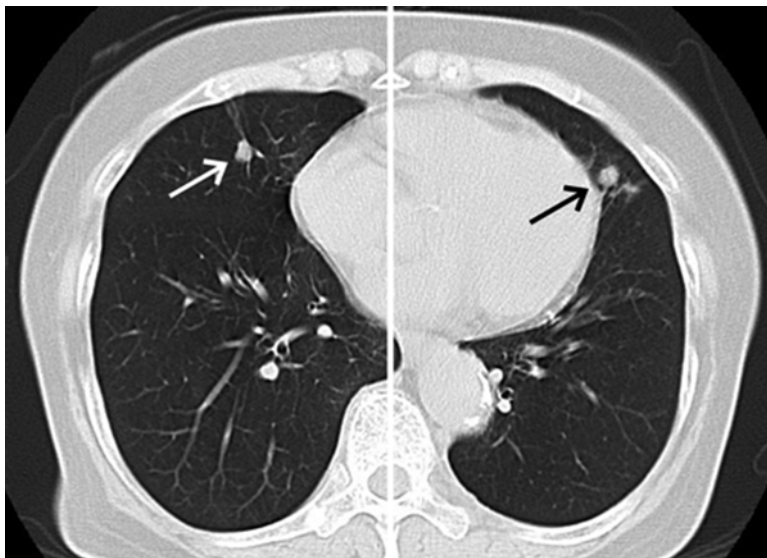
November 2007 chest CT scan showing pulmonary metastases
